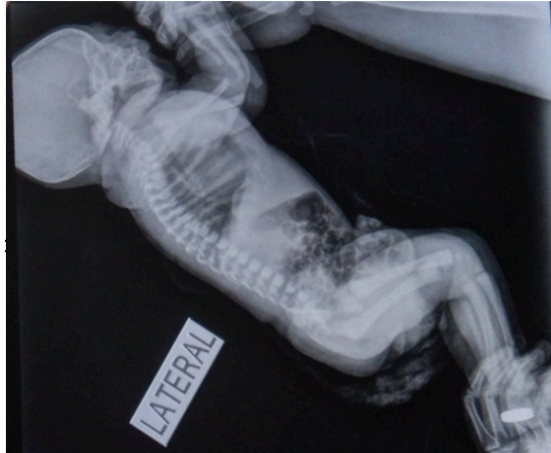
Lateral x-ray showing a grossly normal spine, no defects.
